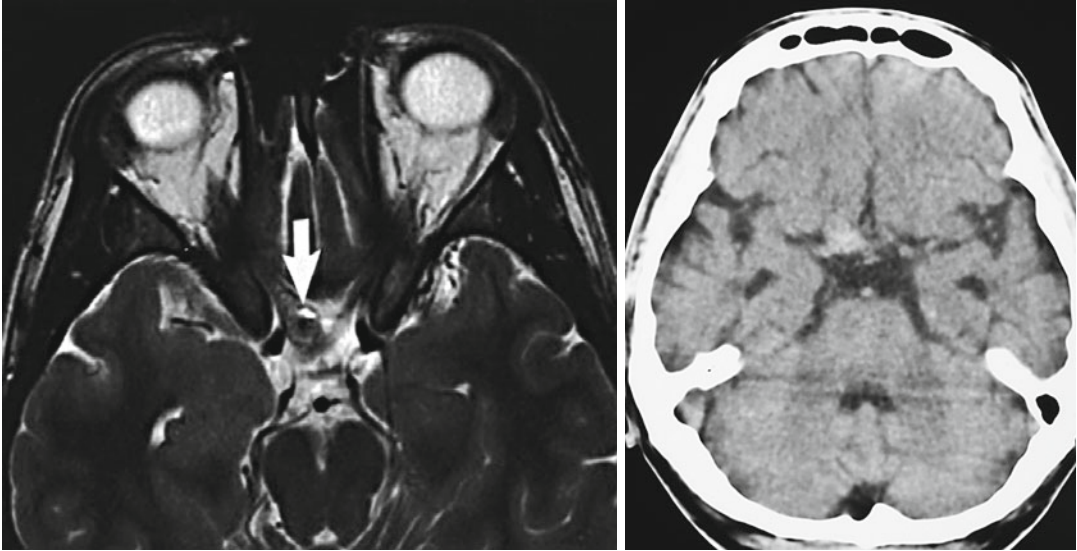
MRI scan showing locational relationships of the cavernoma As the CT scan only proves the presence of hemorrhage, MRI scan is recommended, as the T1 and T2 scans confirm presence of the hemorrhage and provide
